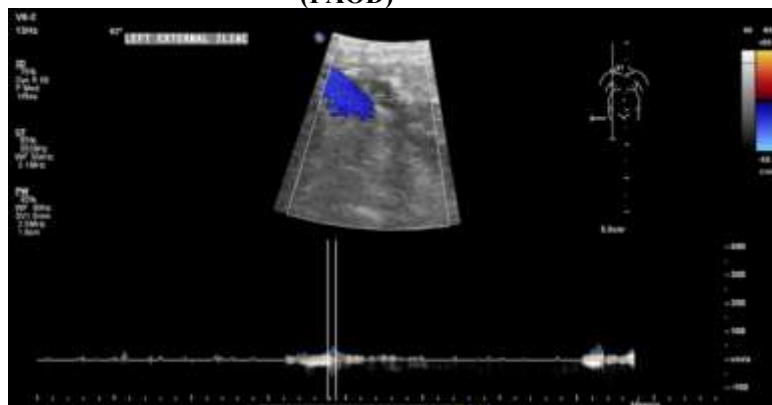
Image e. Color doppler and Spectral waveform image at left external iliac artery showing absence of color flow and spectral waveform. Echogenic content noted causing 100% stenosis - complete occlusion.
